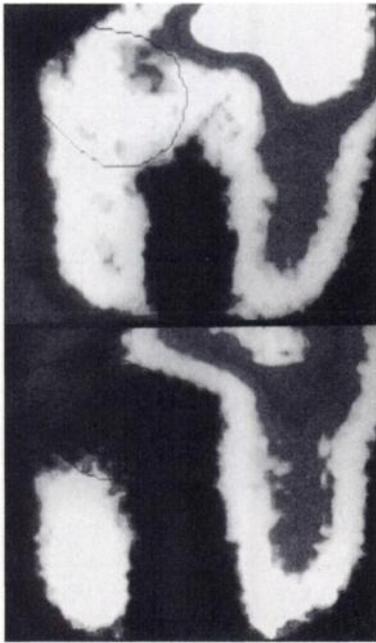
Delayed scintigraphic MIBG images obtained in 1 patient with heart failure because of idiopathic dilated cardiomyopathy, before and 6 mo after addition of metoprolol (top and bottom panel, respectively). Cardiac MIBG uptake was quantified as heart-to-mediastinum activity ratio, using regions of interest positioned over heart and over upper mediastinum. Increase in left ventricular MIBG uptake is noticeable when comparing second to first examination.
